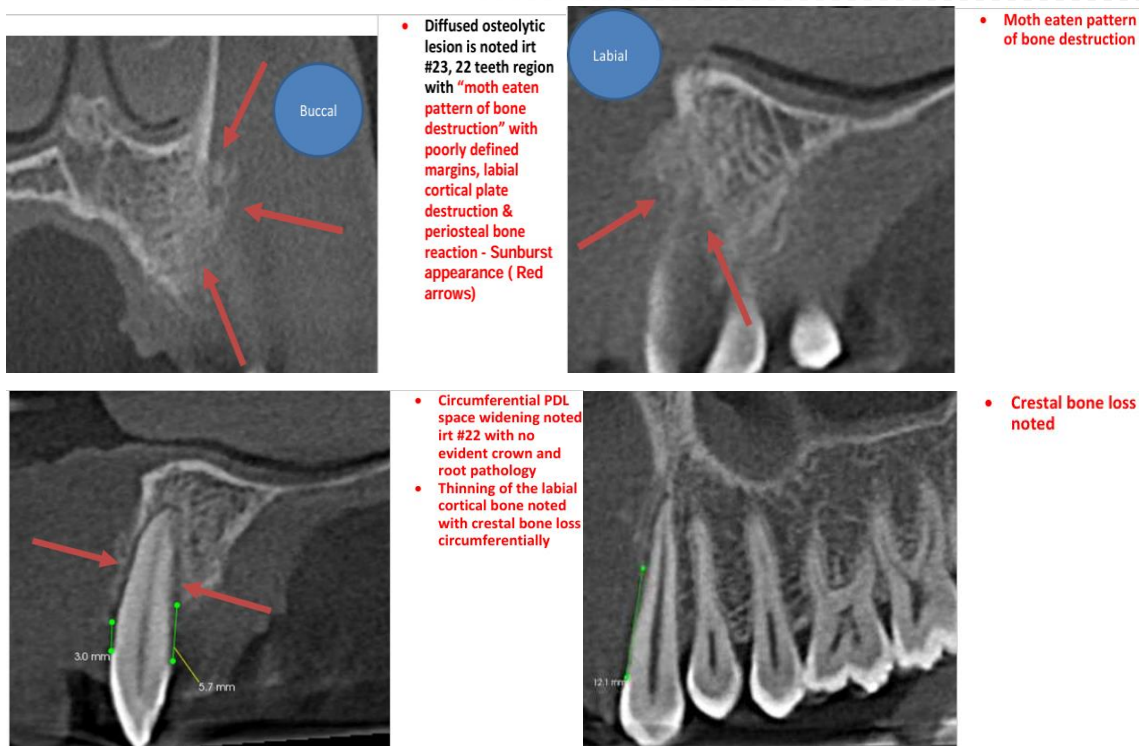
CBCT images demonstrating diffused osteolytic lesion in the left maxillary anterior region (22–23) with moth-eaten pattern of bone destruction, poorly defined margins, labial cortical plate destruction, periosteal reaction (sunburst appearance), circumferential periodontal ligament space widening, and associated crestal bone loss.
